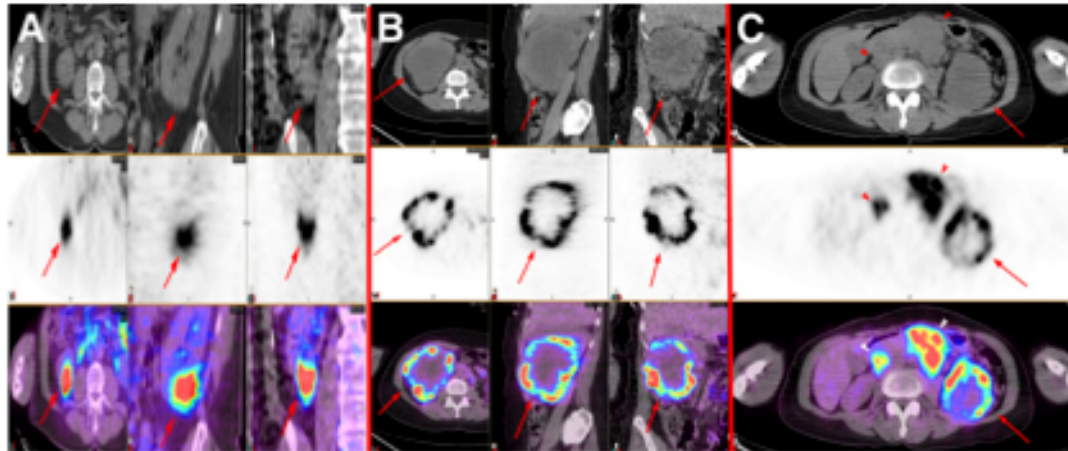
(A and B) Axial, sagittal, and coronal CT (top), PET (middle), and fused PET/CT (bottom) images of patient with clear cell renal cancer with relatively homogeneous distribution of antigen (arrows) (A) and patient with large, centrally necrotic clear cell renal cancer with marked heterogeneity of antigen distribution within mass (arrows) (B). (C) Axial CT (top), PET (middle), and fused PET/CT (bottom) images of patient with advanced clear cell renal cancer. Antigen distribution within primary tumor is heterogeneous (arrows), whereas distribution within metastatic nodes is relatively homogeneous (arrowheads).
